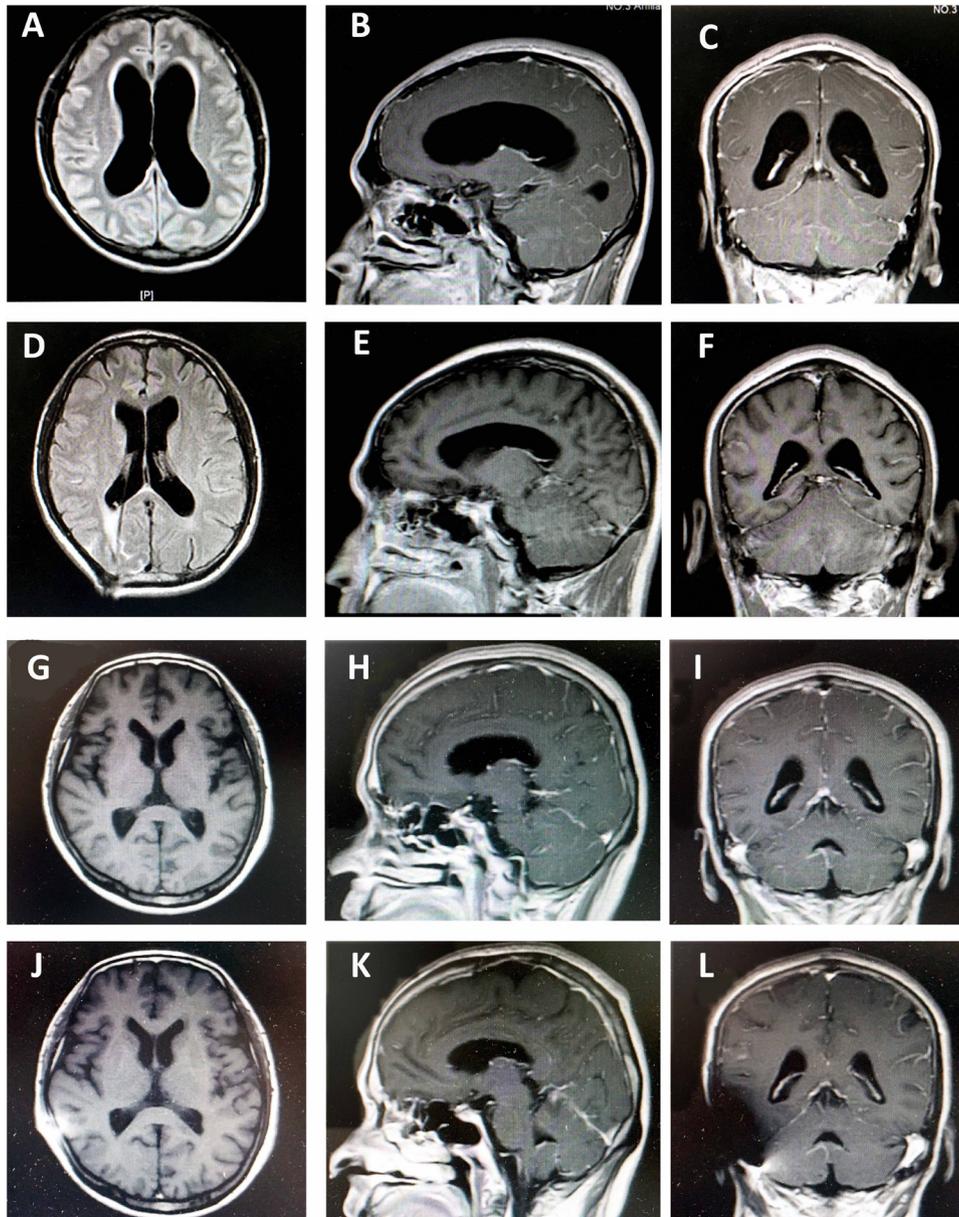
Preoperative and postoperative MRI of the head for a 28-year-old CM patient with ventriculomegaly and a 48-year-old CM patient without ventriculomegaly. The preoperative MRI of the CM patient with high ICP indicated ventriculomegaly (A, horizontal; B, sagittal; C, coronal); the postoperative MRI indicated no ventriculomegaly and ventricular narrowing (D, horizontal; E, sagittal; F, coronal). The preoperative MRI of the CM patient with normal ICP (G, horizontal; H, sagittal; I, coronal); the postoperative CT of the CM patient with normal ICP (J, horizontal; K, sagittal; L, coronal).
